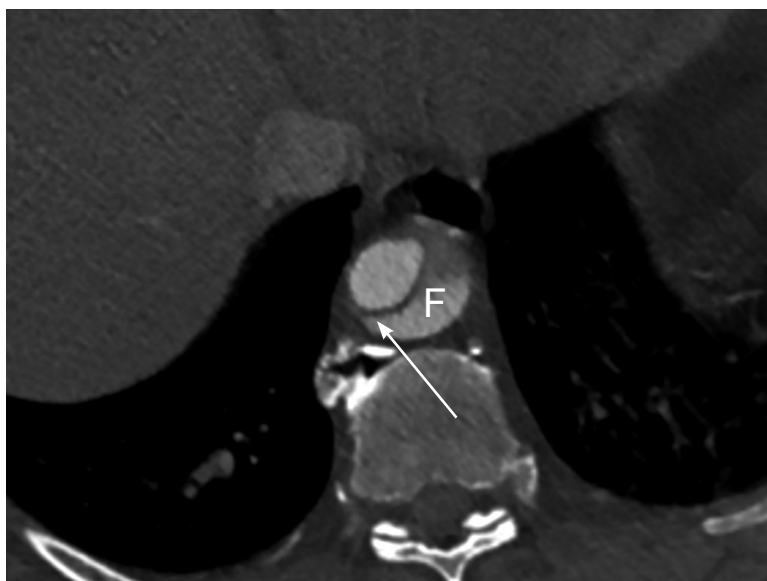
Axial section through the mid ascending and descending aorta on a computed tomography angiogram, demonstrating the acute angle between the dissection flap and the aortic wall (arrow). This acute angle or beak sign occurs on the side of the false lumen (F).
